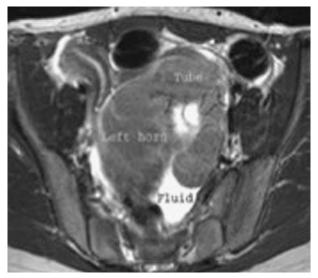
Axial T2-weighted magnetic resonance image of pelvis before outside surgery. Magnetic resonance image shows a normal right uterine horn (RT) separated from the left horn by a thin low-signal fibrous band.
